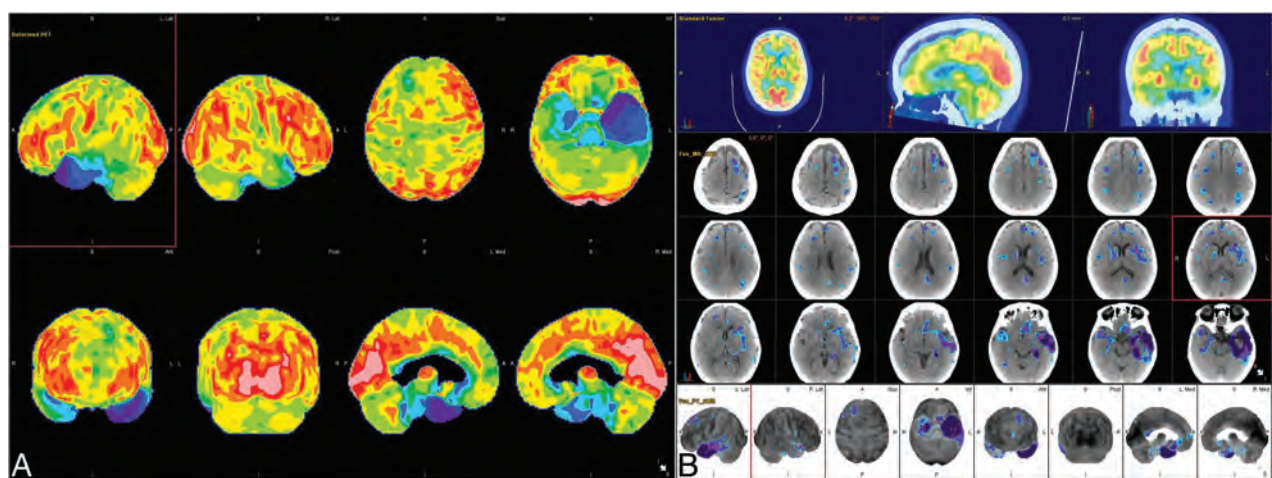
[^{18}F] FDG-PET cortical surface maps demonstrate an abnormal FDG distribution pattern with severe left and moderate right hypometabolism in the anterior temporal lobes (A), with corresponding disproportionate cortical atrophy, particularly pronounced in the left temporal pole visualized on brain CT images (B), findings further supported by semiquantitative FDG-PET analysis using z scores calculated in comparison with findings in age-matched cognitively healthy controls, semiquantitative FDG-PET analysis demonstrate markedly decreased values in the temporal lobes including the temporal poles (left > right) (B).
